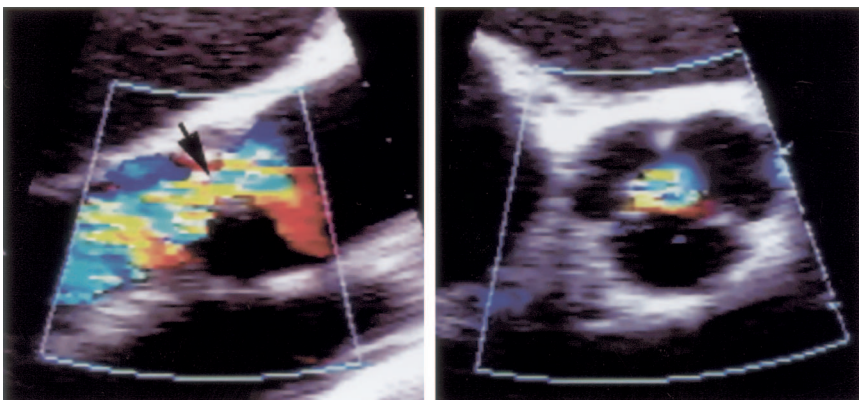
Vena contracta images of AR jet by transesophageal echocardiography in long-axis (left) and short-axis (right) views. The vena contracta is seen as the narrowest part of the jet as it emerges from the regurgitant orifice. The short-axis view is difficult to orient precisely in the plane of the vena contracta but is useful in determining whether the jet is central and round (in which case the long-axis vena contracta accurately describes AR severity) or markedly elliptical, as in bicuspid aortic valves (in which the long-axis vena contracta may underestimate AR severity). Reprinted from Willett et al,⁴⁴ copyright 2001, with permission from the American College of Cardiology Foundation.
